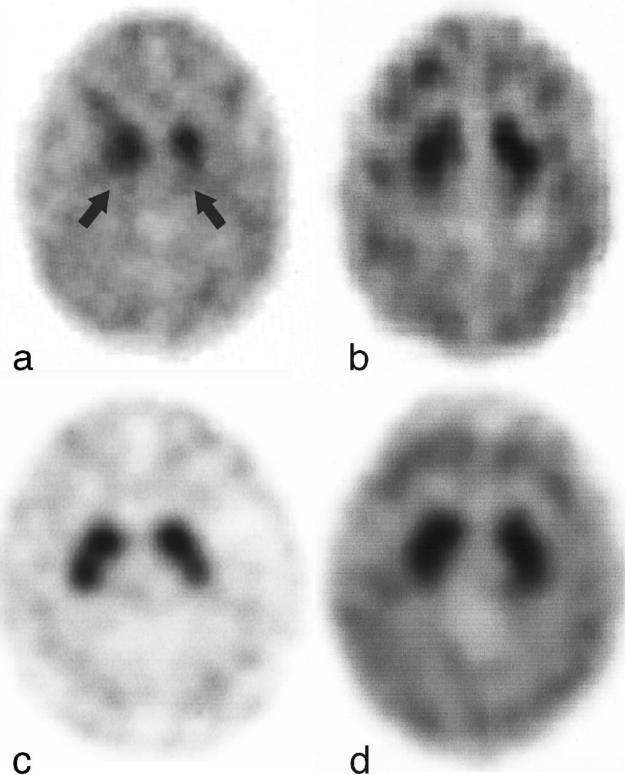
(a) [<sup>123</sup>I] N-omega-fluoropropyl-2beta-carbomethoxy-3beta-(4-iodophenyl)nortropine (FP-CIT) SPECT of the CHS patient shows significantly lowered tracer uptake of the putamen on both sides (arrows). (b) Iodobenzamide (IBZM) SPECT of the patient with CHS. (c) Example of a normal [<sup>123</sup>I] FP-CIT SPECT. (d) Example of a normal IBZM SPECT.
